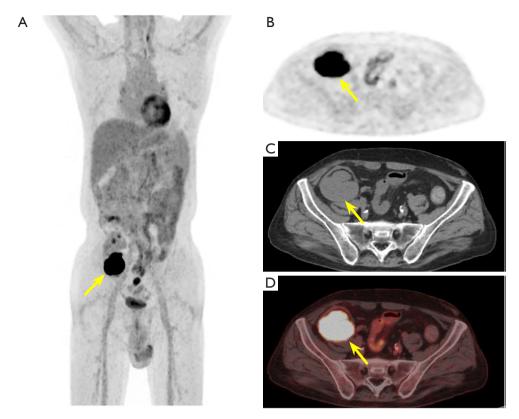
¹⁸F-FDG whole body PET/CT findings for the patient. (A) The MIP image showed a significantly high uptake mass in the lower pole of the atrophic kidney graft (SUVmax =19.4), and a high uptake lesion at the rectosigmoid junction (SUVmax =6.2). PET (B), CT (C), and fused PET/CT (D) of the cross section showed an abnormal FDG-avid lesion in the kidney graft. No other foci of abnormally high radioactive uptake were observed in the rest of the entire body. The yellow arrows indicate the location of the lesion in the kidney graft. FDG, fluorodeoxyglucose; PET/CT, positron emission tomography-computed tomography; MIP, maximal intensity projection; SUVmax, standardized uptake value maximum.
